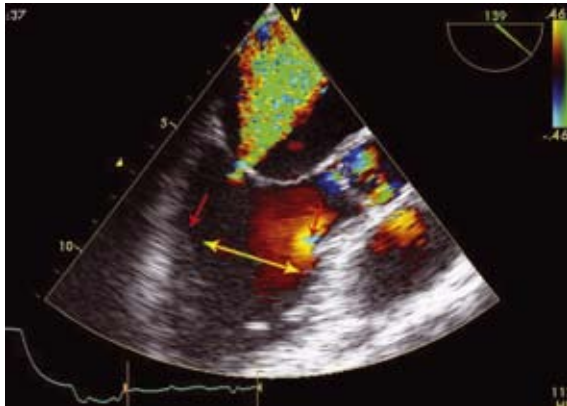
On transesophageal echocardiography, severe preoperative mitral regurgitation and increased papillary muscle distance is observed in the ventricle long-axis view. AQ: 1
